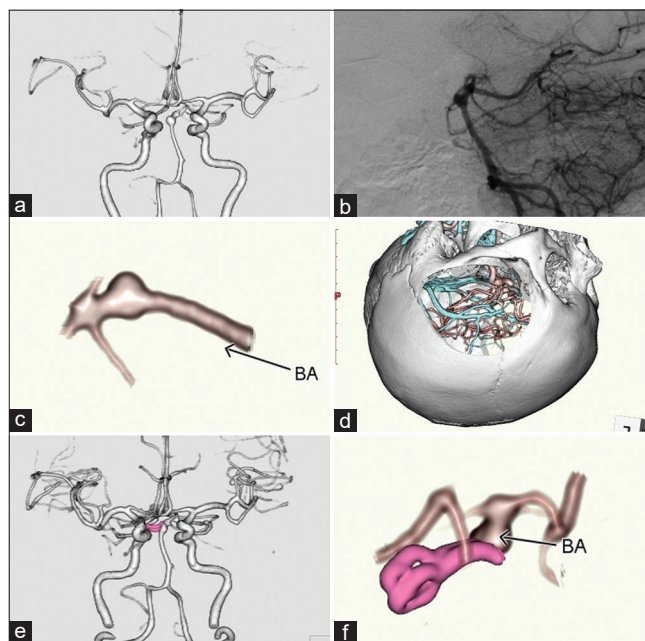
(a) Preoperative three-dimensional computed tomography angiographic anteroposterior view showing basilar trunk aneurysm; (b) lateral view in digital-subtraction angiography; (c) reconstructed isolated image of basilar artery with trunk aneurysm; (d) three-dimensional computed tomography angiography and venography with removal of bone; (e) postoperative three-dimensional computed tomography angiographic image showing clipped basilar trunk aneurysm; (f) three-dimensional computed tomography reconstructed angiographic images of isolated basilar artery with clip on trunk aneurysm
